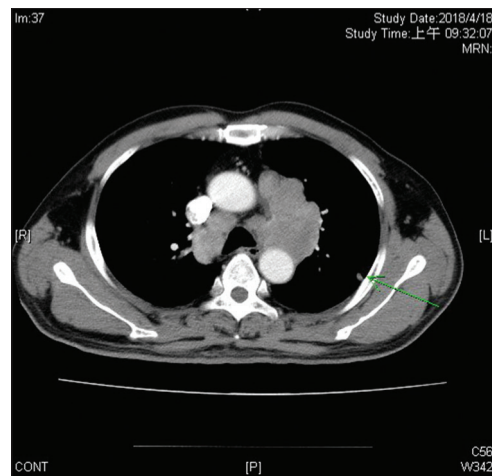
Chest computed tomography showed confluent enlarged lymph nodes at the mediastinum and clustered small lung nodules (green arrow) in the left upper lobe
